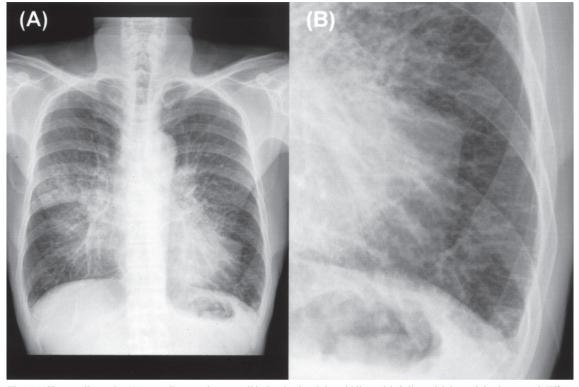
Chest radiographs (A) revealing patchy consolidation in the right middle and left lingual lobes of the lungs and diffuse interstitial line thickening of both lung zones, (B) Kerley's B lines are seen in the magnified image.
